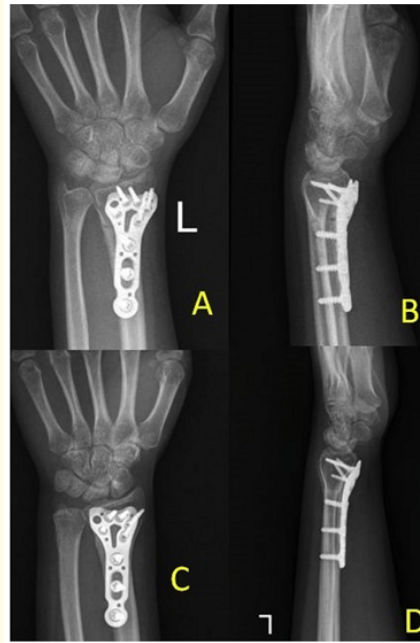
Immediate postoperative radiographs (A and B) of a 23 years female shows stage II Kienböck's disease treated with radial shortening osteotomy. After a 1 year follow-up, PA radiograph (C) and lateral radiograph (D) showed resolution of sclerosis and restoration of lunate height.
